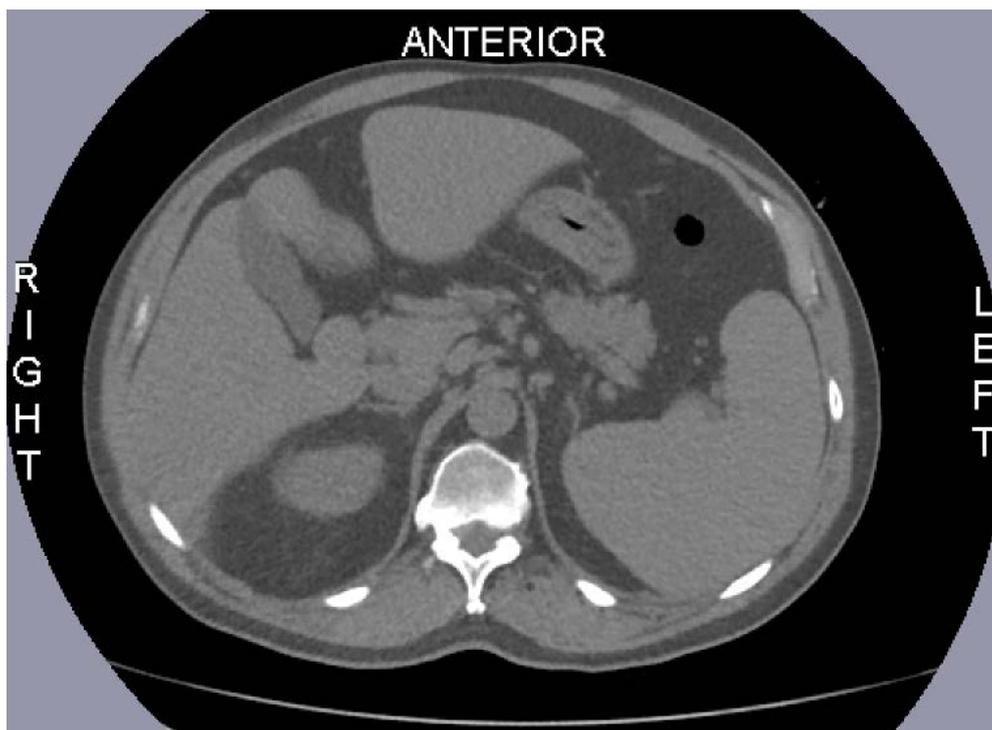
Original CT scan at TH12.
